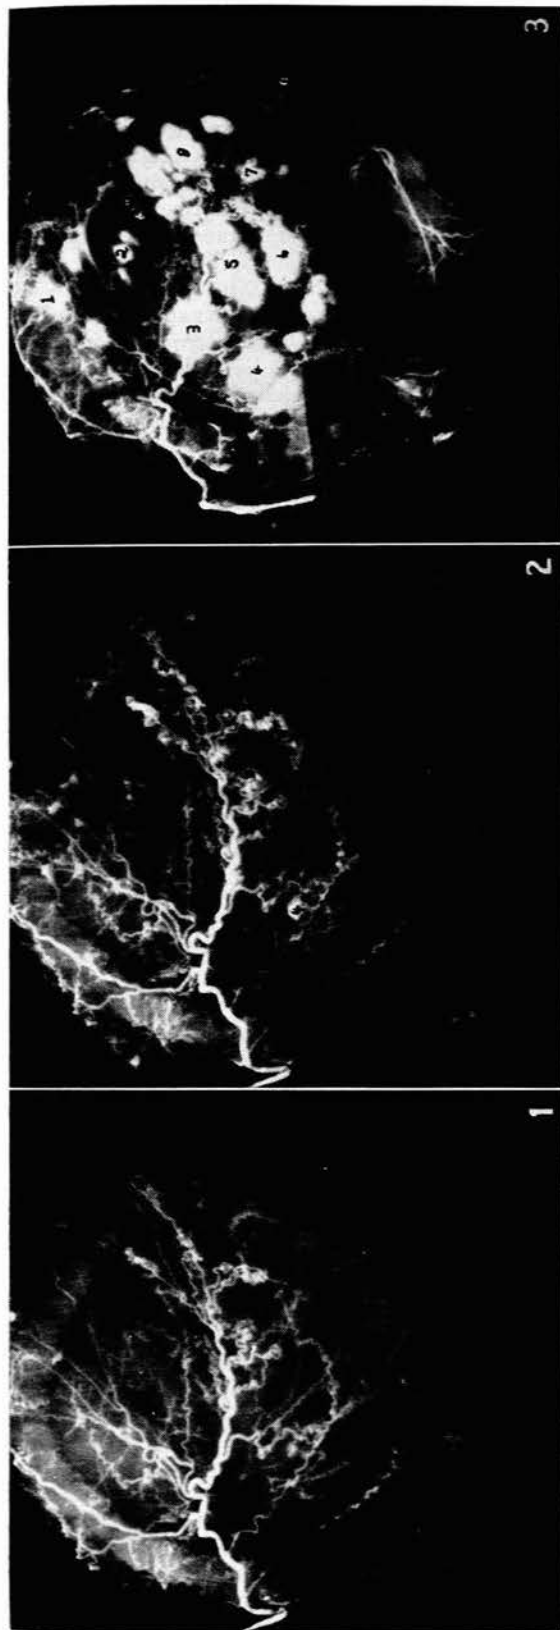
X-ray taken 2 seconds after the injection was begun and after approximately 20 ml. of radio-opaque dye had been injected into the right uterine artery. Fig. 2. X-ray taken after 4 seconds and after approximately 32 ml. of dye had been injected. Fig. 3. X-ray after 80 ml. of radio-opaque dye had been injected.
